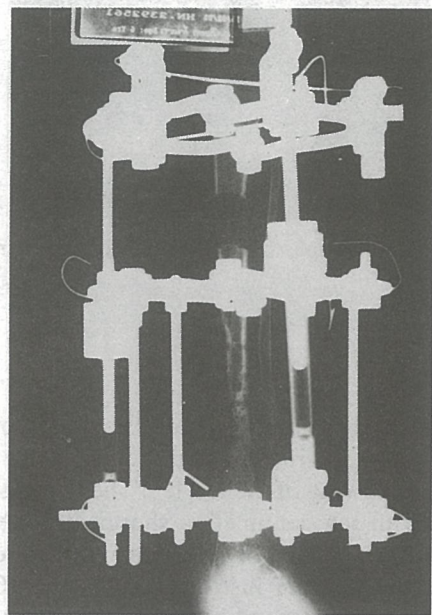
The radiograph showing congenital pseudarthrosis of the tibia after removal of the plate and application of a ring external fixator.
